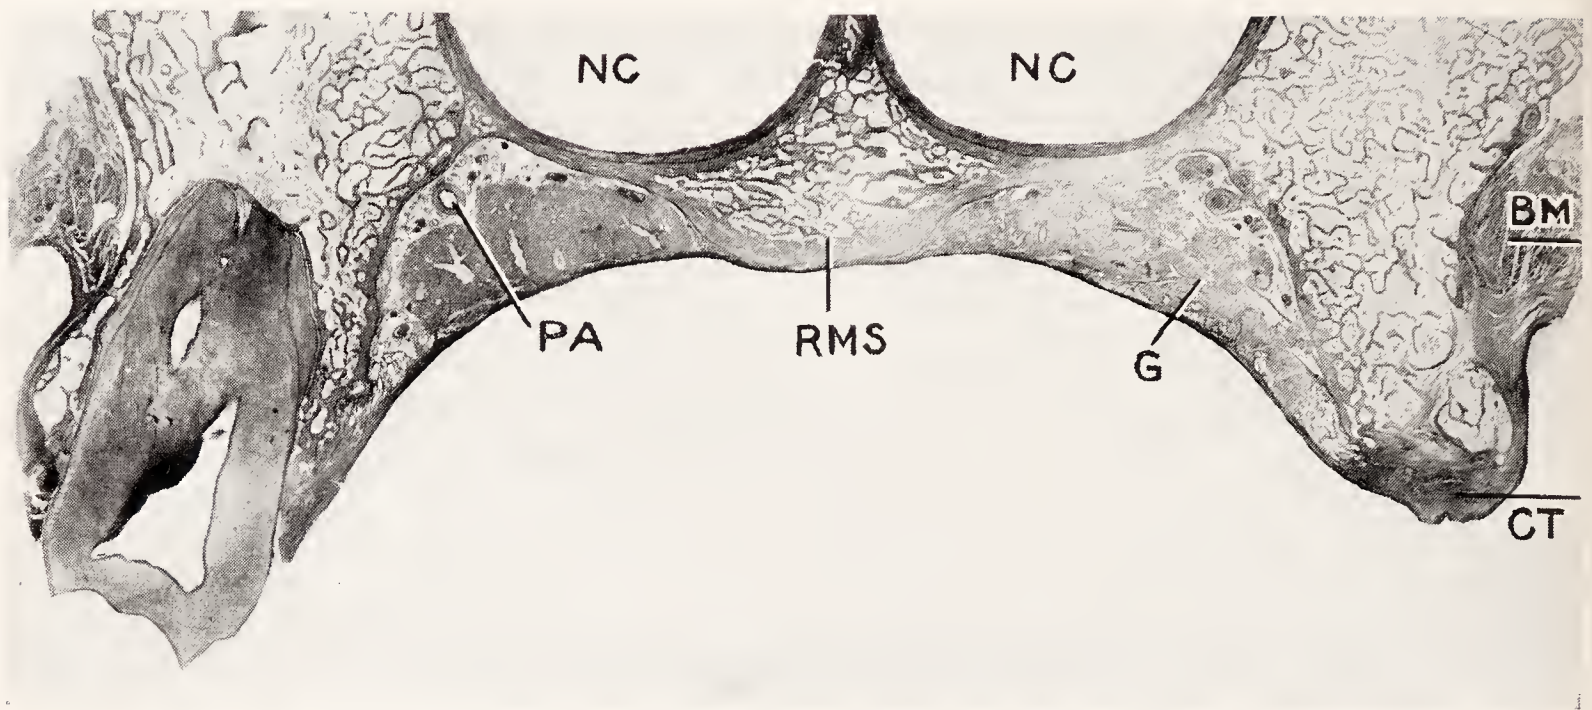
Frontal section through an upper jaw in the third molar region. The upper left third molar is intact; the right side of the maxilla is edentulous. *NC*, nasal cavity; *BM*, buccinator muscle; *CT*, fibrous connective tissue; *G*, mucous glands of palate; *RMS*, bony ridge of maxillary suture; *PA*, palatine artery. (Pendleton, Jour. Am. Dent. Assn.)
